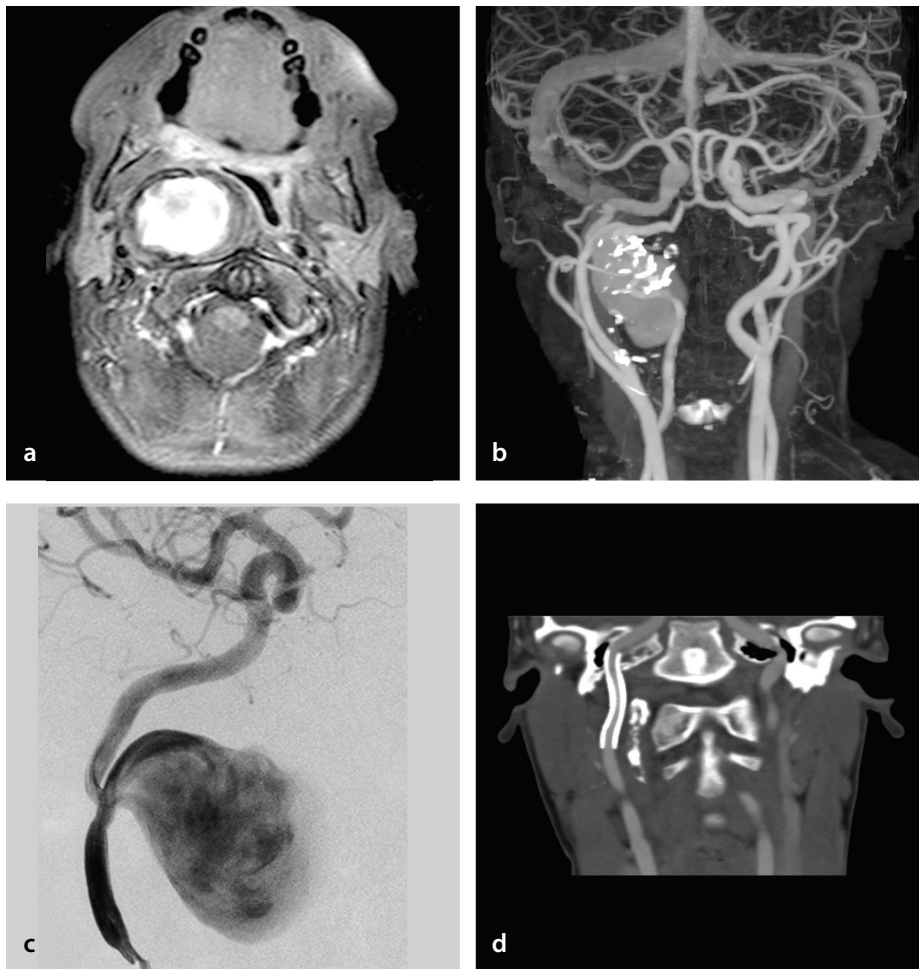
Patient 1: Chronic traumatic aneurysm (a). Magnetic resonance imaging shows a huge mass compressing the esophagus and laryngeal air passage. (b) Subtracted computed tomography (CT) angiography reveals the aneurysm with extensive wall calcification. (c) Angiography demonstrates a huge aneurysm arising from the pre-petrous segment of the right internal carotid artery. (d) One-year follow-up CT angiography confirms the disappearance of the aneurysm and shrinkage of the mass.
